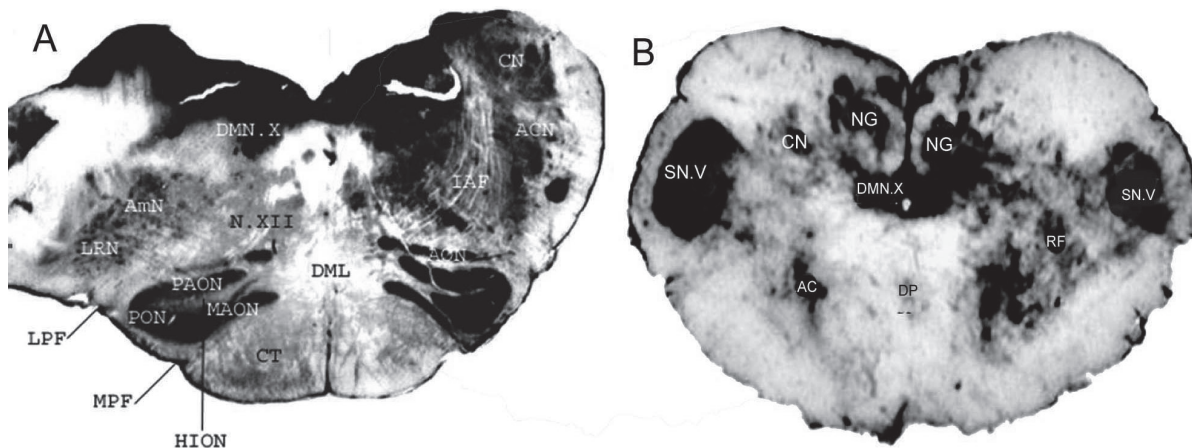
A - Transverse section of the medulla oblongata at the area postrema and the inferior olive level. Cuneate nucleus (CN); Accessory cuneate nucleus (ACN); Internal arcuate fibers (IAF); Accessory olivary nucleus (AON); Decussation of the medial lemniscus (DML); Corticospinal tract (CT); Dorsal motor nucleus of the vagus nerve (DMN.X); Ambiguous nucleus (AmN); Lateral reticular nucleus (LRN); Hypoglossal nerve (N.XII); Posterior accessory olivary nucleus (PAON); Principal olivary nucleus (PON); Medial accessory olivary nucleus (MAON); Hilus of the inferior olivary nucleus (HION); Lateral paraolivary fissure (LPF); Medial paraolivary fissure (MPF). B) Cross section of the medulla oblongata at the level of the decussation of the pyramids. Spinal nucleus of the trigeminal nerve (SN.V); Cuneate nucleus (CN); *Nucleus gracilis* (NG); Dorsal motor nucleus of the vagus nerve (DMN.X); Accessory nucleus (AC); Decussation of the pyramids (DP); Reticular formation (RF)
